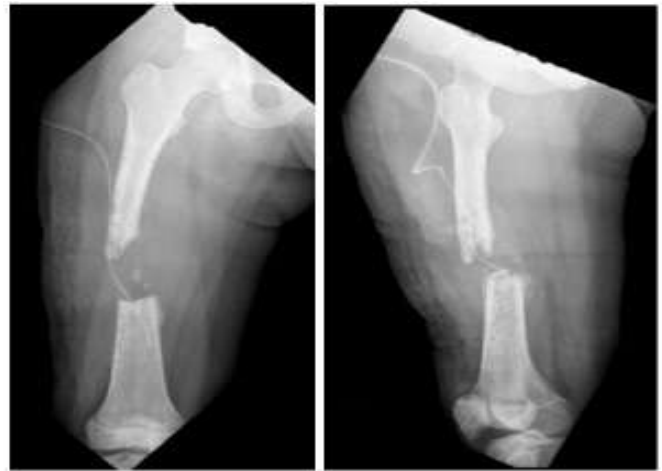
Post-operative X-Ray after sequestrectomy and the application of skeletal traction.
